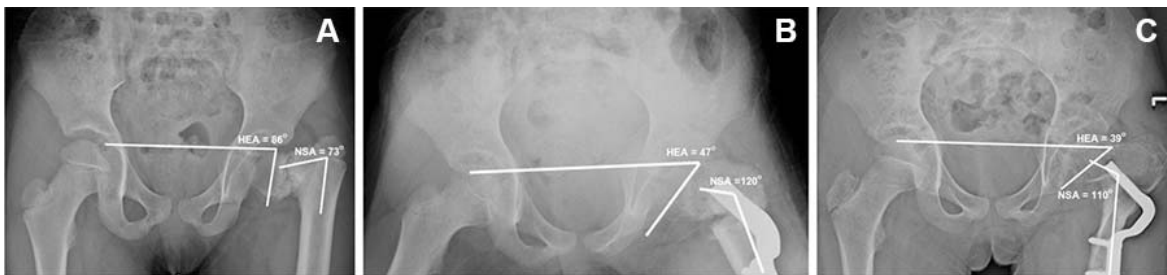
The radiograph both hips of 7-year-old female came with coxa vara from congenital coxa vara (Case No. 11) show Hilgenreiner-epiphyseal angle and neck-shaft angle at preoperative, 12 weeks postoperative and final follow-up at 3 years postoperative.
